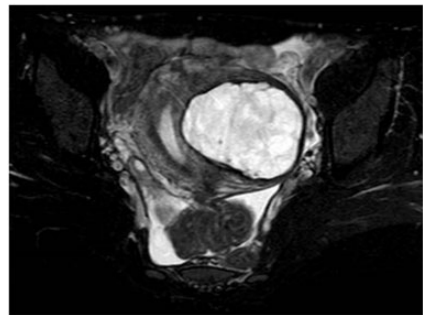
Axial MRI T2-weighted fat-suppressed sequence demonstrating the local lesion with an inhomogeneous hyperintensity on the left uterine side wall.
